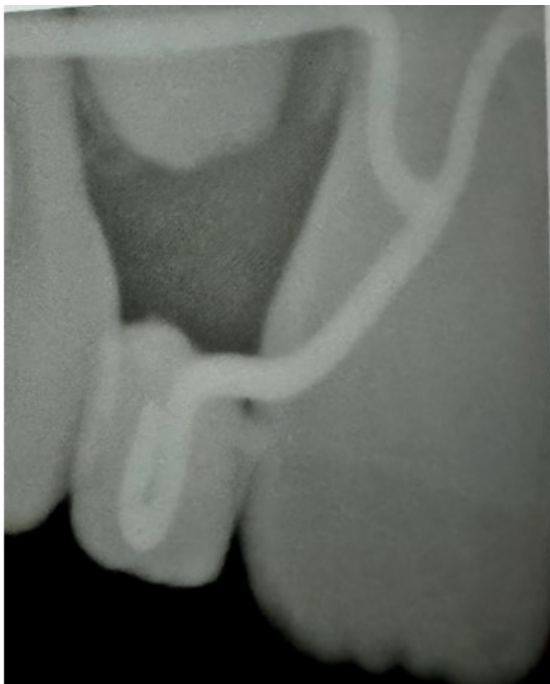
Radiograph showing luxatemp tooth incorporated with finger spring
